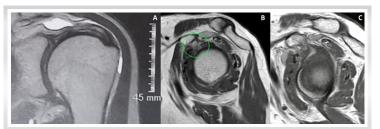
T2 MRI images displaying subdeltoid and subcoracoid bursitis (a) and the presence of signs of adhesive capsulitis at the rotator interval (b and c).
